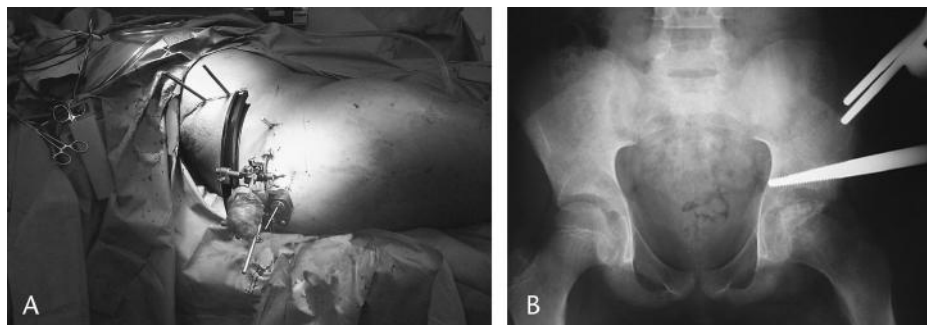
A, Intraoperative picture demonstrating Schanz pins inserted between the medial and lateral walls of the ilium. B, AP left hip x-ray showing the proximal montage.
